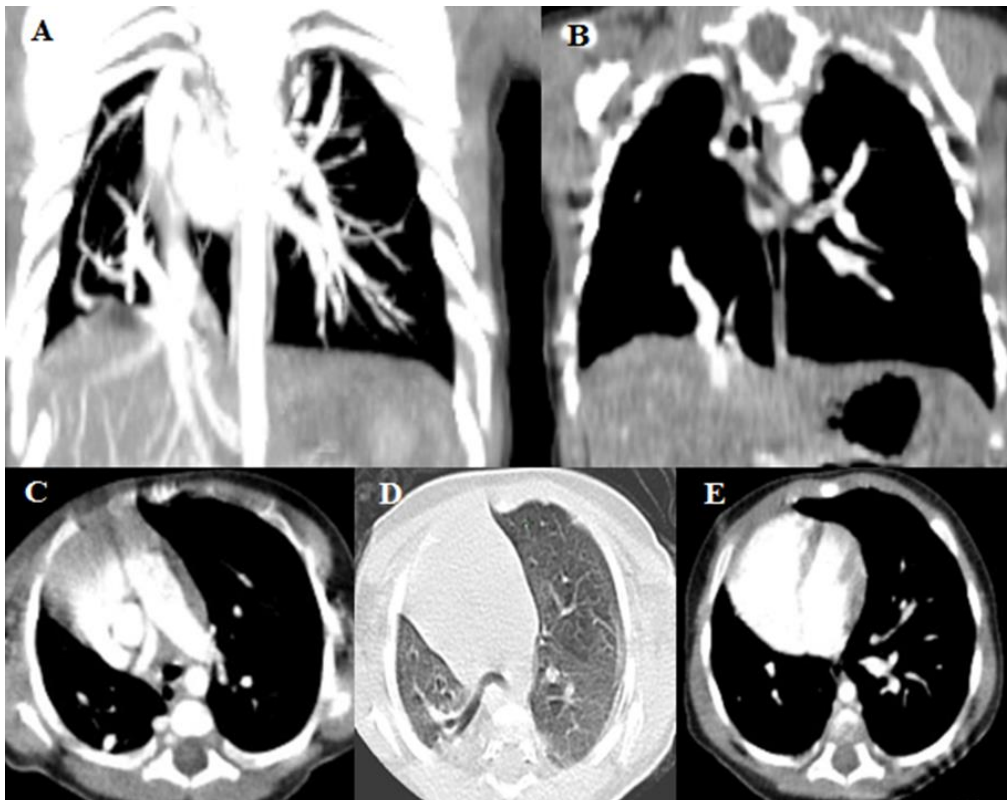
A, B: computed tomography scan (Coronal section) showing an abnormal right pulmonary venous return to the inferior vena cava C: Hypoplasia of the right pulmonary artery D: Right pulmonary hypoplasia E: Dilatation of cardiac cavities, paradoxical septum
